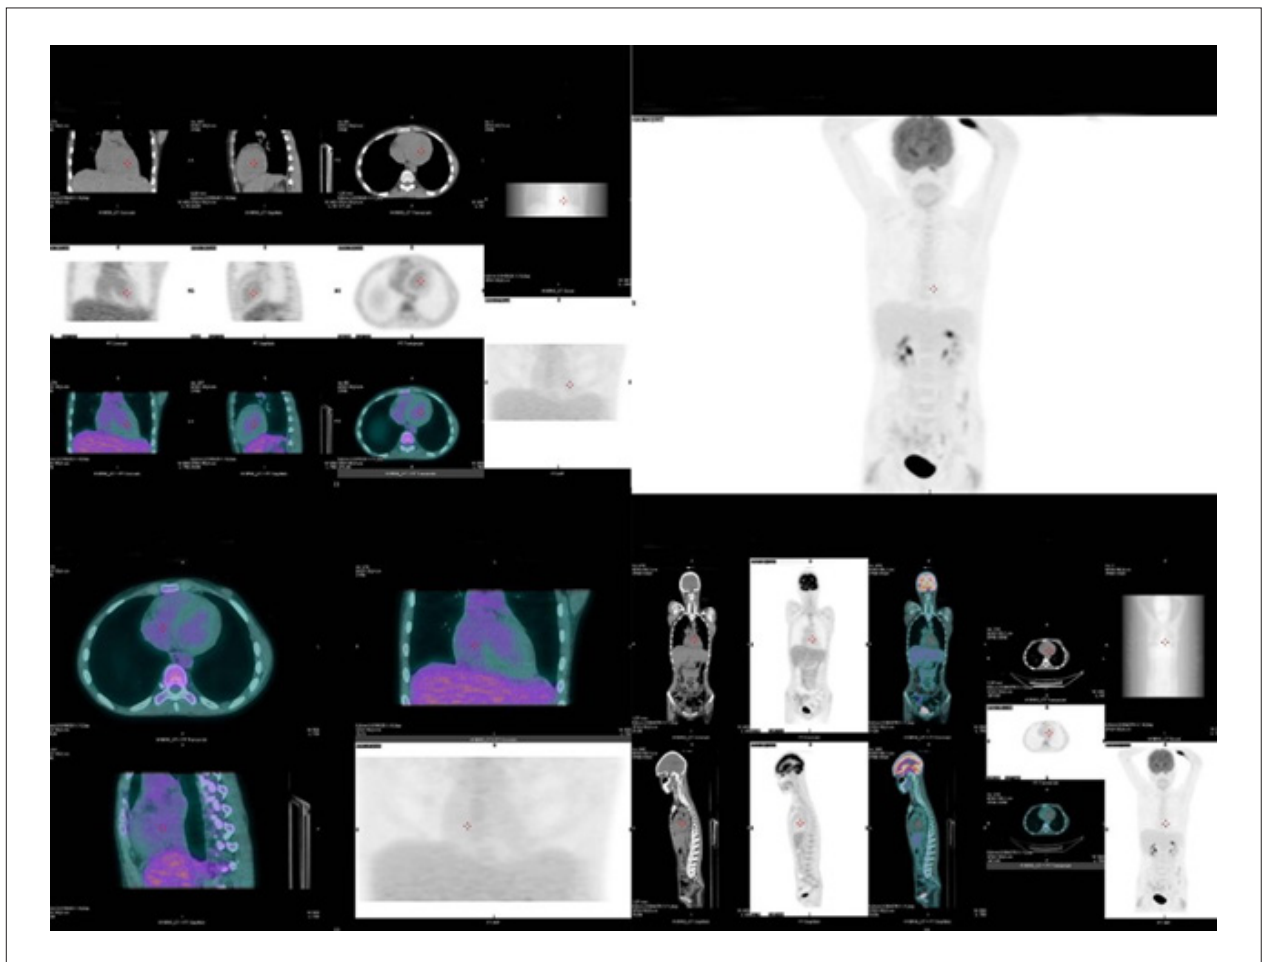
¹⁸F-FDG PET-CT in post-treatment lupus myocarditis: Complete regression of uptake is observed after 2 months of immunosuppressant treatment.
